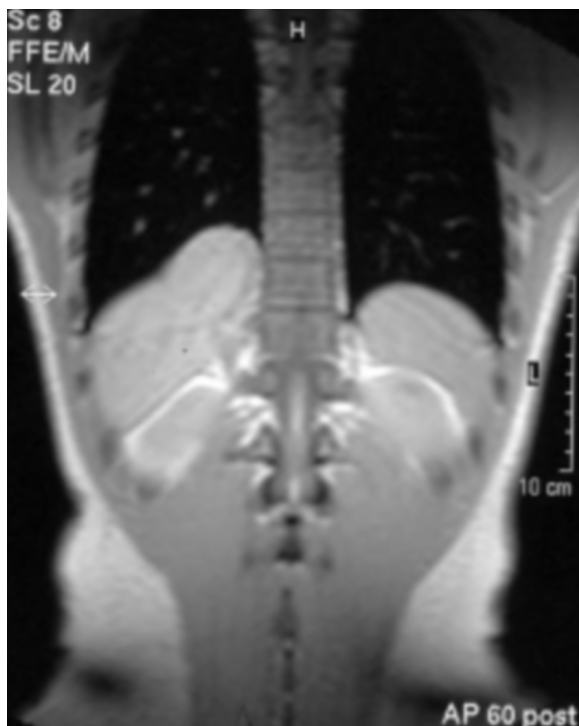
Coronal T1-weighted MRI reveals a portion of liver herniated through a defect in the posterior right hemidiaphragm.
